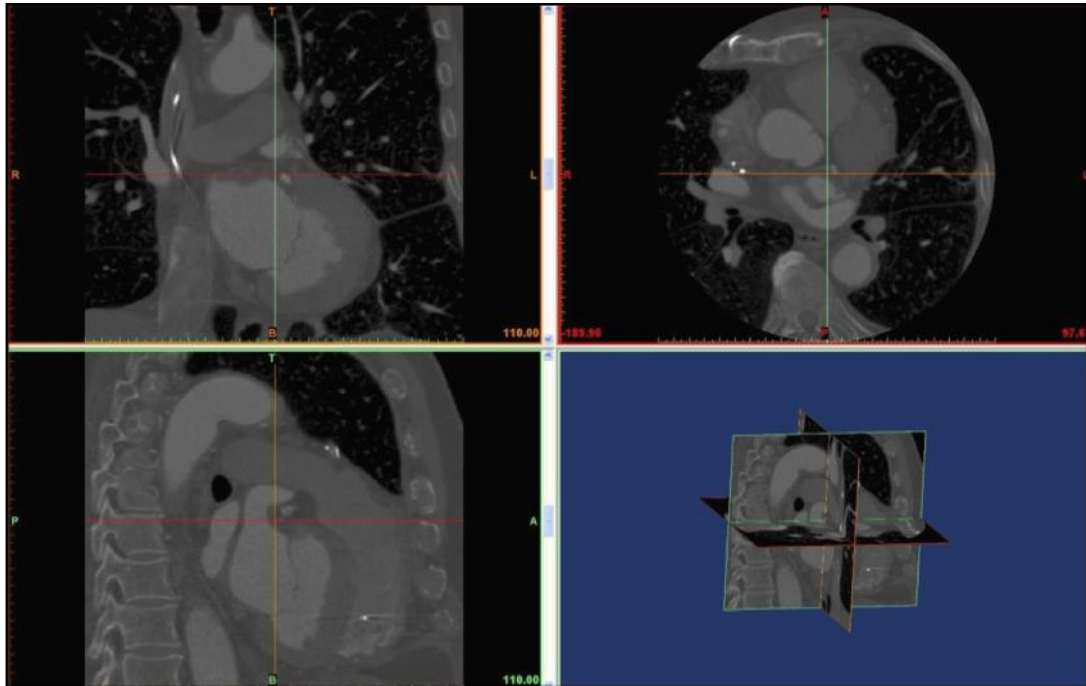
2D CT scan slices, right view, left view, top view and perspective
